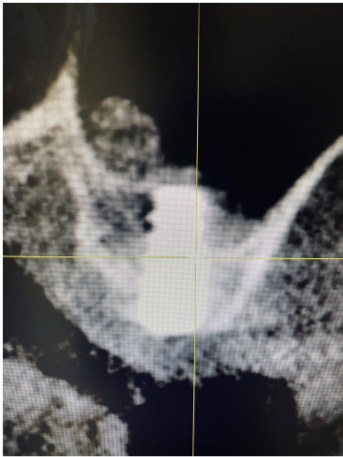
CBCT post to shows the bone augmentation
